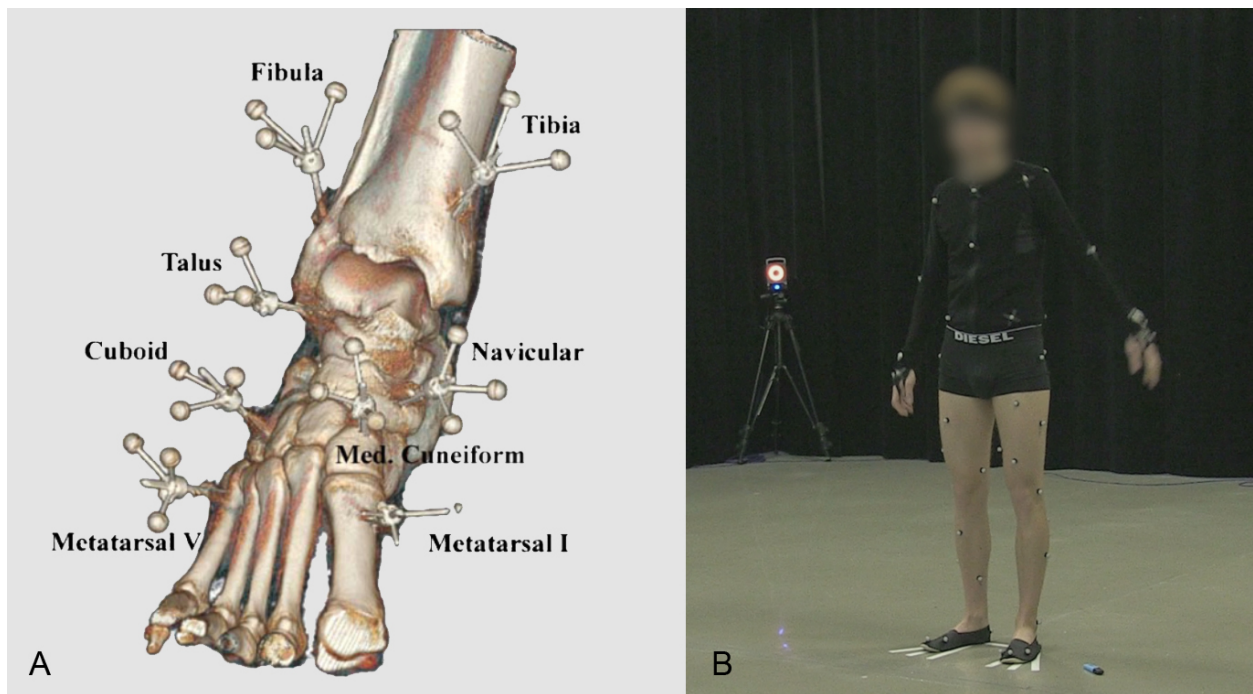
A) CT image of bone pins inserted into the foot. Image from [LNL⁺08] used with permission. B) Full body motion capture with a focus here on the lower extremities (markers are placed directly on the skin).
